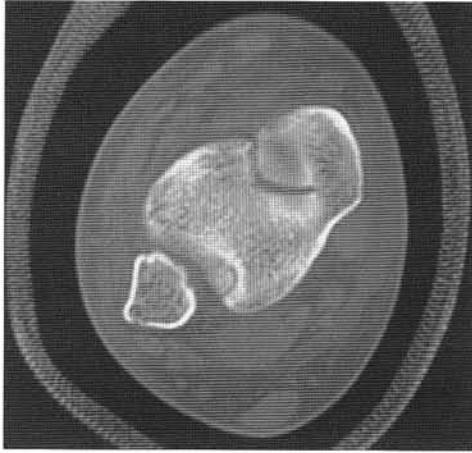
Computed tomography of the articular surface of the tibial plafond.
